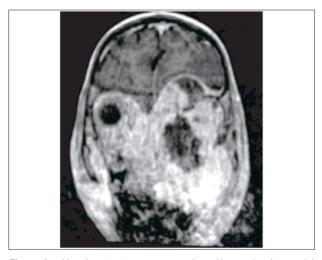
Very important tumor progression with massive intracranial extension under chemotherapy. MRI axial, spin-echo T1-weighted images, following gadolinium administration
